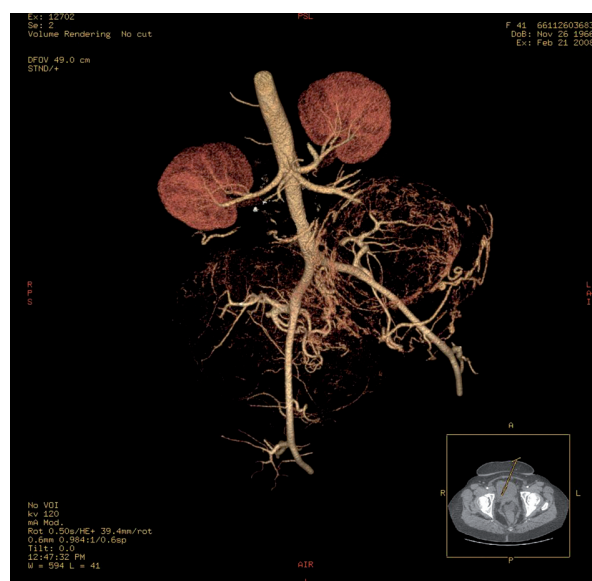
Angio-computed tomography scan, 3-D reconstruction: irregular vessels of fibroid mass
